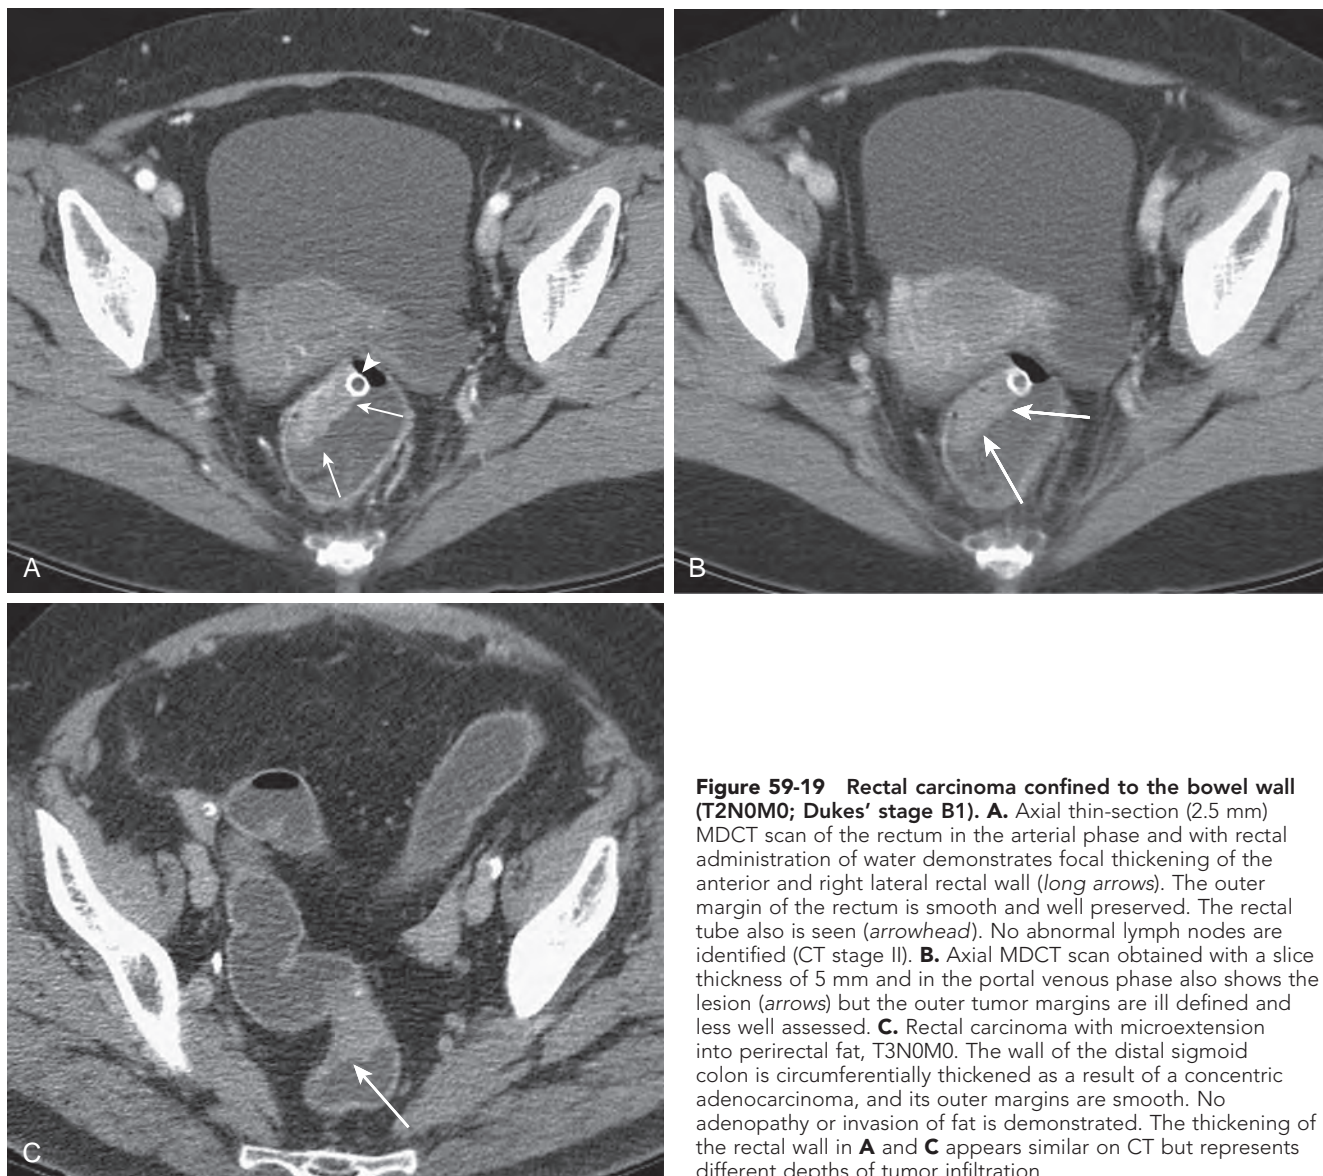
Rectal carcinoma confined to the bowel wall (T2N0M0; Dukes' stage B1). A. Axial thin-section (2.5 mm) MDCT scan of the rectum in the arterial phase and with rectal administration of water demonstrates focal thickening of the anterior and right lateral rectal wall (long arrows). The outer margin of the rectum is smooth and well preserved. The rectal tube also is seen (arrowhead). No abnormal lymph nodes are identified (CT stage II). B. Axial MDCT scan obtained with a slice thickness of 5 mm and in the portal venous phase also shows the lesion (arrows) but the outer tumor margins are ill defined and less well assessed. C. Rectal carcinoma with microextension into perirectal fat, T3N0M0. The wall of the distal sigmoid colon is circumferentially thickened as a result of a concentric adenocarcinoma, and its outer margins are smooth. No adenopathy or invasion of fat is demonstrated. The thickening of the rectal wall in A and C appears similar on CT but represents different depths of tumor infiltration.
